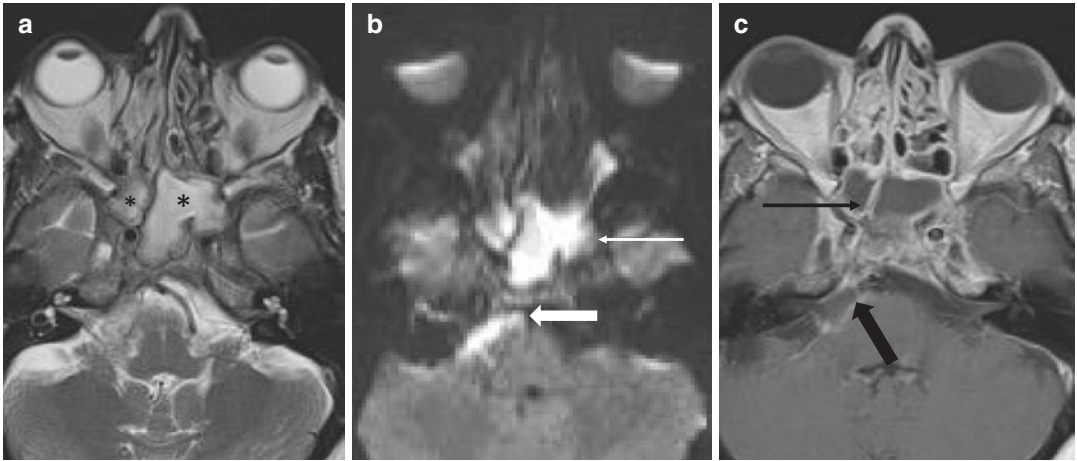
(a) Axial T2 weighted MRI showing complete opacification of both sphenoid sinuses (asterisk). (b) DWI sequence showing elevated DWI signal in the sphenoid sinuses (thin white arrow) and the prepontine cistern (thick white arrow). (c) Axial contrast enhanced T1 weighted MRI showing peripheral enhancement of the sphenoid sinuses (thin black arrow) and meningeal enhancement along the right pons (thick black arrow)
